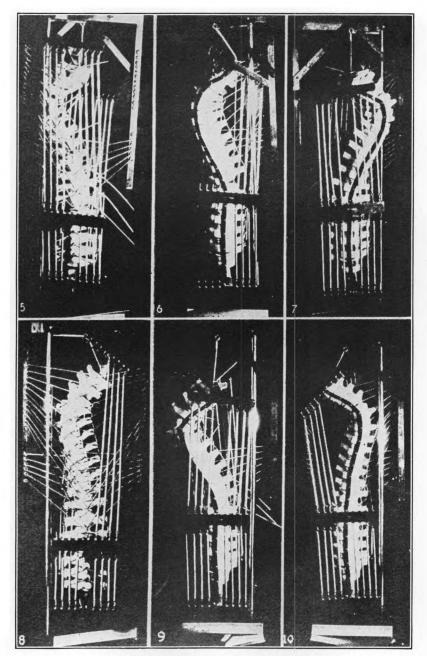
VENTROLATERAL ASPECT OF THE DYNAMIC MUSCLE-BONE BALANCE MODEL OF THE HUMAN SPINE.
